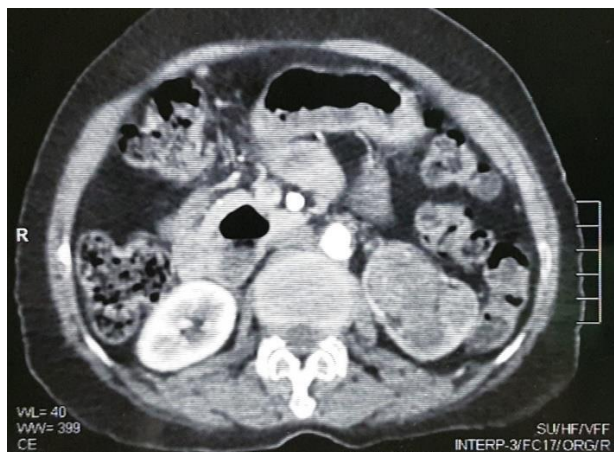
CT scan showing large heterogeneously enhancing mass lesion in the pelvicalyceal system of the left kidney infiltrating into left renal cortex.
